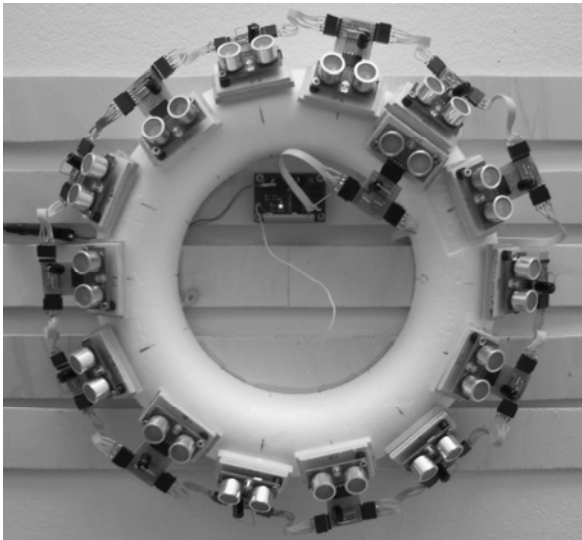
Ultrasonic ring prototype with 15 ultrasonic sensors attached (bottom view)
